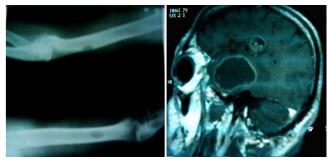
X-ray showing metastases in the distal part of left humorous and brain
